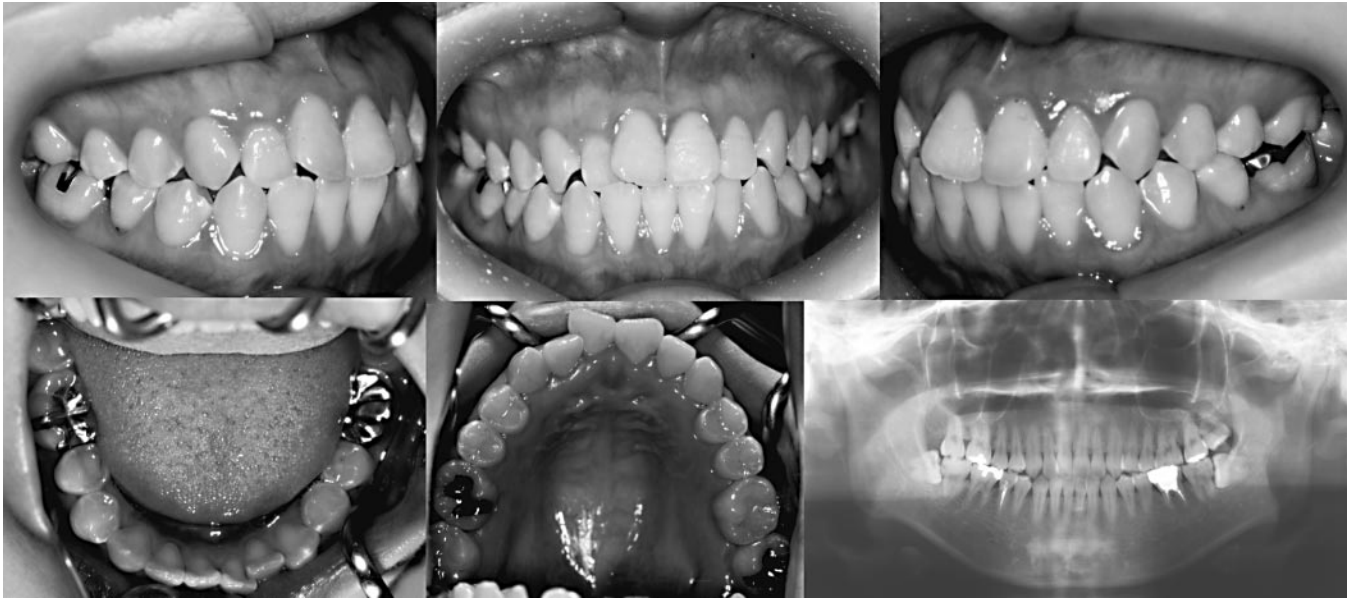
Initial intraoral photographs and panoramic radiograph. Panoramic radiograph was taken after initial treatment of dental caries and restorations.
